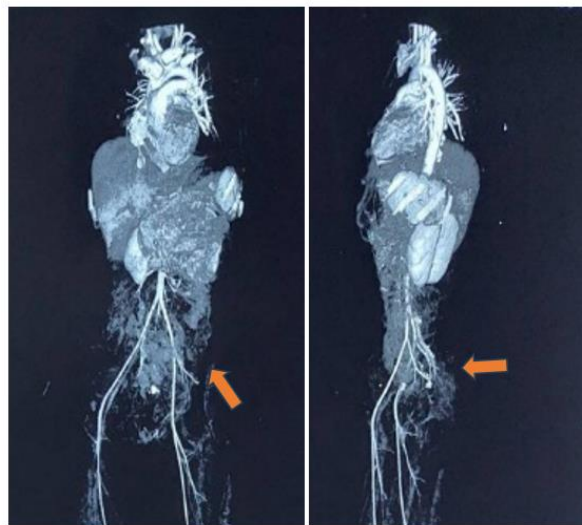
The result of CT angiography confirmed communication with anomalous vessels refer to left uterine arterio-venous malformation (arrow).
